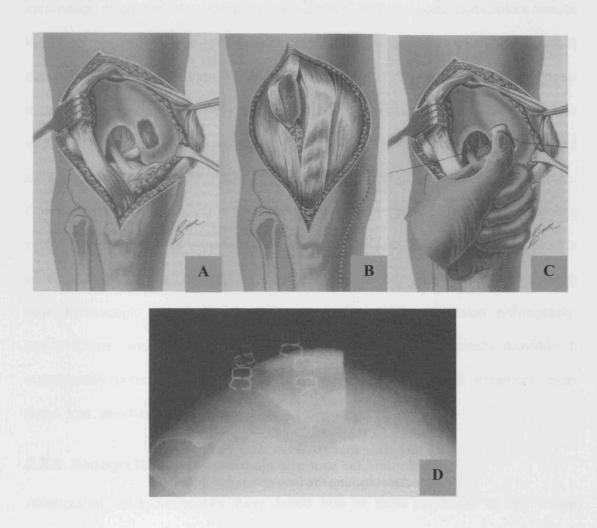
A procedure carried out by Outerbridge where an autograft harvested from the lateral half of the patella (B) was used to graft a defect (A) of the medial femoral condyle (C) (Outerbridge, 1995). In (D) a postoperative radiograph demonstrating the result (Jacobs, 1965) is shown.
